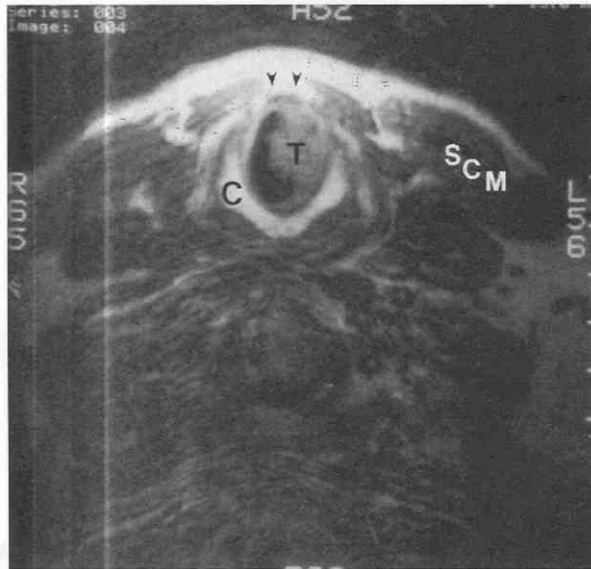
Vocal cord lesion with subglottic extension. T1-weighted MRI study. The patient presented with a lesion of the true cord (not shown). The tumor (T) is within the ring of the cricoid cartilage (C). Note the intact fat planes (*arrowheads*) just anterior to the cricothyroid membrane. SCM, sternocleidomastoid. (From Curtin HD: *Imaging of the larynx: Current concepts*. Radiology 173:1-11, 1989.)
